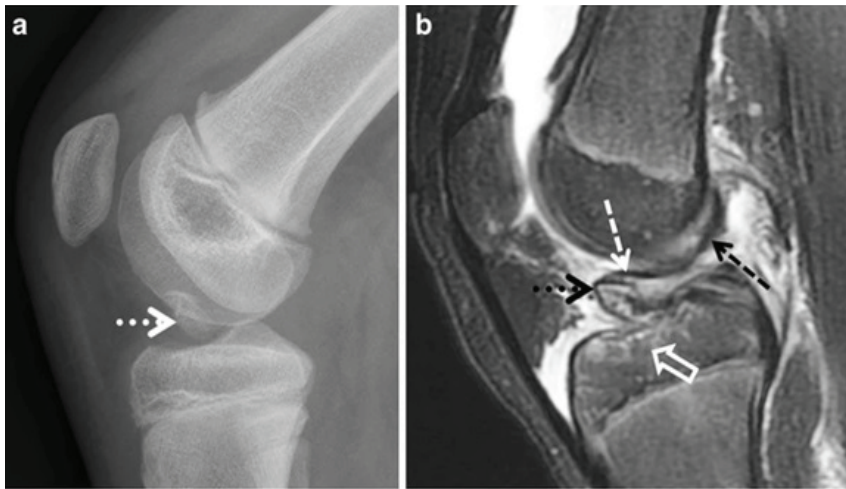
Paediatric knee traumatic sports injury. Left image is a lateral knee x-ray depicting a fracture fragment projected over anterior aspect of intercondylar fossa. Right image is a matching sagittal fluid sensitive MRI sequence of the same knee demonstrating a displaced avulsion fracture of the ACL tibial footprint and exuberant surrounding marrow and soft tissue oedema with effusion.
